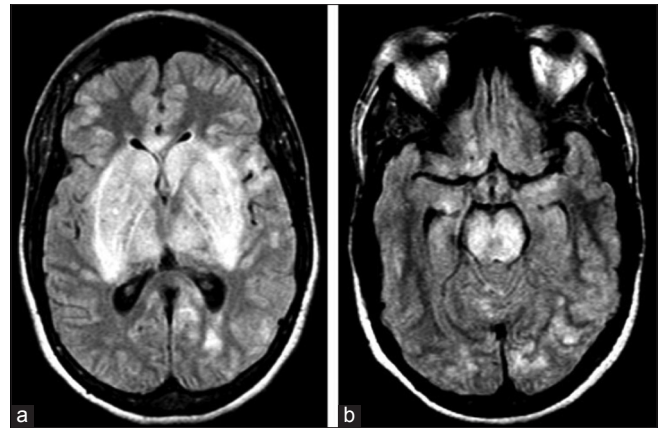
A 36-week pregnant woman presented with a history of eclampsia. (a) Axial fluid-attenuated inversion recovery (FLAIR) magnetic resonance imaging (MRI) shows symmetric edema in the thalami and basal ganglia. (b) Axial FLAIR MRI shows diffuse edema in the pons. Follow-up MRI obtained 2 months later was normal posterior reversible encephalopathy syndrome
